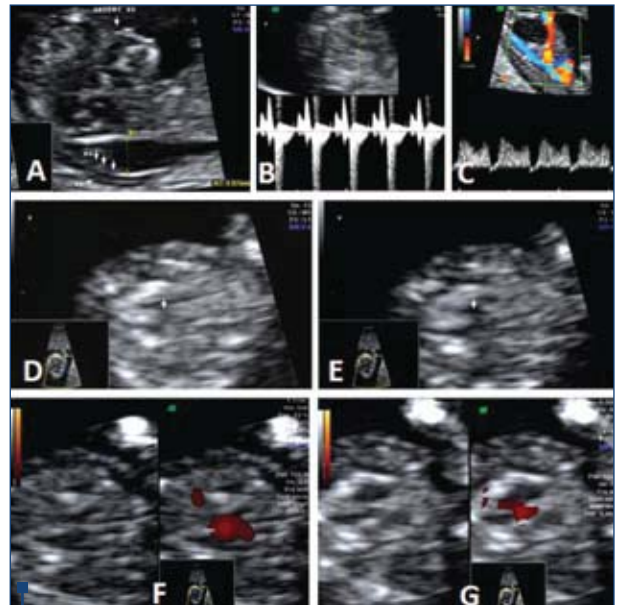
Fetus with trisomy 21 showing abnormal morphological features at 11-14 weeks genetic screening. A: sagittal sectional plane of the fetal face showing increased nuchal translucency and absent nasal bone. B: assessment of the tricuspid valve, showing tricuspid regurgitation. C: sagittal sectional plane of the fetal trunk: reverse "a" wave in ductus venosus assessment by color and pulsed Doppler assessment; megacystis (longitudinal diameter 14.1mm) is obvious in the same plane. D,E: axial plane at the level of the fetal thorax, at the level of the cardiac four-chamber view, suggesting septal defect (arrow). F,G: duplex display (gray-scale and power Doppler) confirming the suspected septal defect
